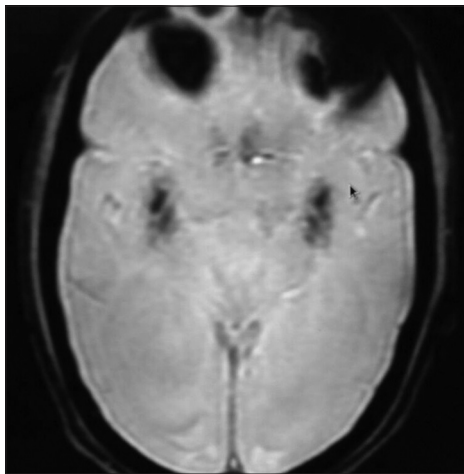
MRI GRADIENT axial image showing bilateral basal ganglia calcification
